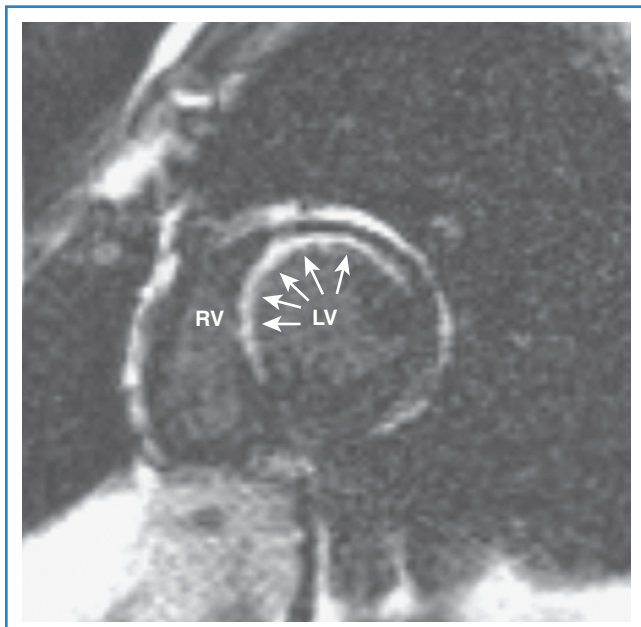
Ischemic myocardial scar. Delayed enhancement magnetic resonance imaging demonstrating a transmural scar (arrows) along the septal, anteroseptal, and anterior walls of the left ventricle. RV, right ventricle; LV, left ventricle. (Courtesy Dr. Jean Jeudy.)
